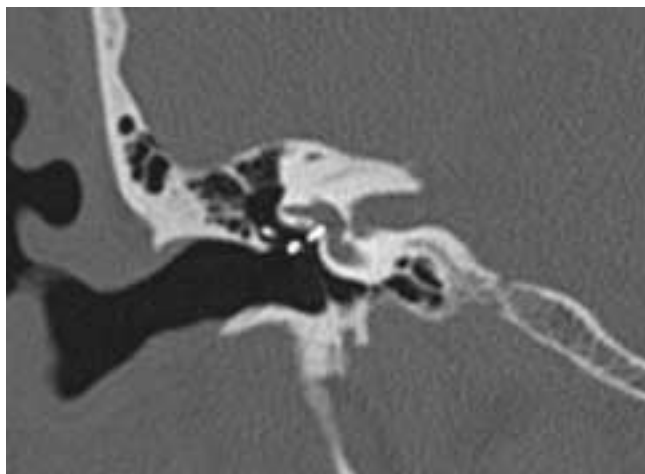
Coronal fenestral otosclerosis after stapedotomy and insertion of the prosthesis. Coronal CT image of the right ear demonstrates the prosthesis inserted into the oval window.
